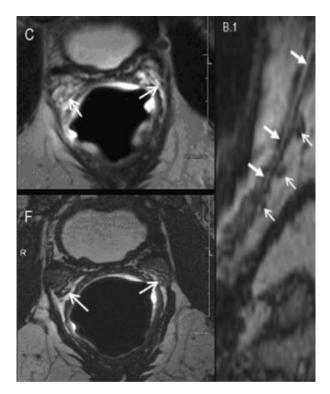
A 64-year-old man after radical retropubic prostatectomy (preoperative International Index of Erectile Function Five-Item [IIEF-5]: 22 points; postoperative IIEF-5 at 6 months: 8 points; postoperative IIEF-5 at 12 months: 9 points). C and F = axial sections at 6 months (C) and 12 months (F) after surgery obtained by 3D T2-weighted isotropic image at the level of prostatic fossa. The arrows indicate neurovascular bundle (NVB) location. Radiologists assessed bilateral low signal intensity on left and right NVBs at both times of examination. B.1 = left side coronal multiplanar reconstructions obtained by axial 3D sequence (6-month evaluation); NVB anatomical course is evaluable (arrows). NVB delineation results in good appearance (arrows). After evaluating this image, the radiologists assessed this patient as class 0 under the MRI classification score.
